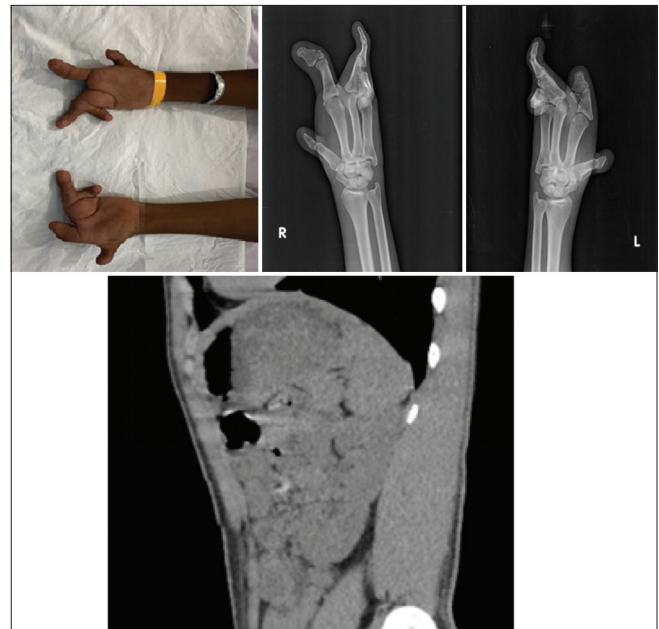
Clinical photograph and X-ray wrist joint AP show oligodactyly, absent bilateral thumb, syndactyly and deformed, and fused carpal bones in both hands. Coronal section of plain CT abdomen showing normal position of the left kidney and right renal agenesis.
